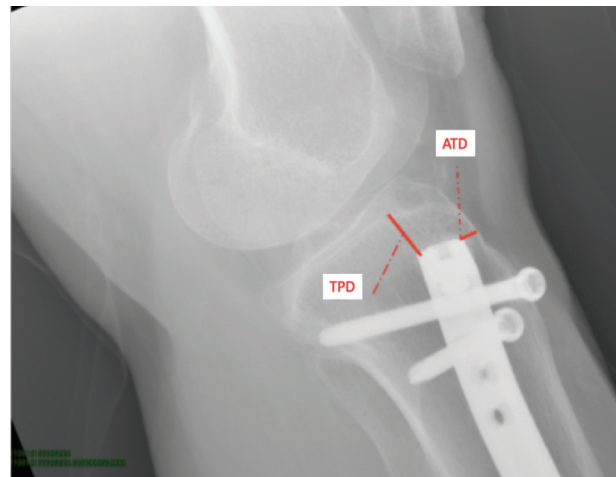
Pre-operative X-Ray that shows the tibial plateau distance (TPD) that is the distance between the apex of the nail and the tibial plateau and the anterior tibial distance (ATD) that is the distance from the apex of the nail and the anterior tibial profile
